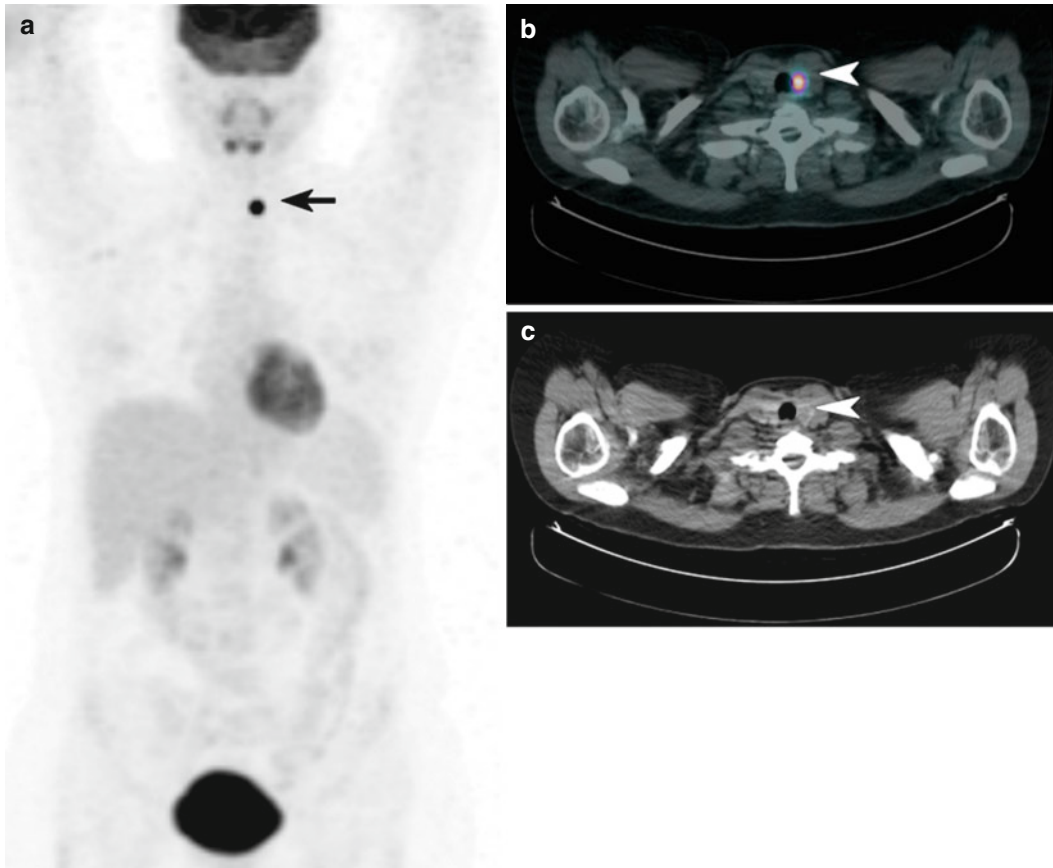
A 38-year-old woman with widespread lymphadenopathy and suspected lymphoma underwent a FDG PET-CT scan for further investigation. (a) Maximum intensity projection (MIP) PET and (b) fused axial PET-CT images revealed intense focal FDG uptake within the left lobe of thyroid with a SUV_{max} of 17.4 (arrow and arrowhead), localising to (c) a 13 mm hypodense thyroid nodule with small areas of calcification on the concurrent low-dose CT scan (arrowhead). There was very mild
